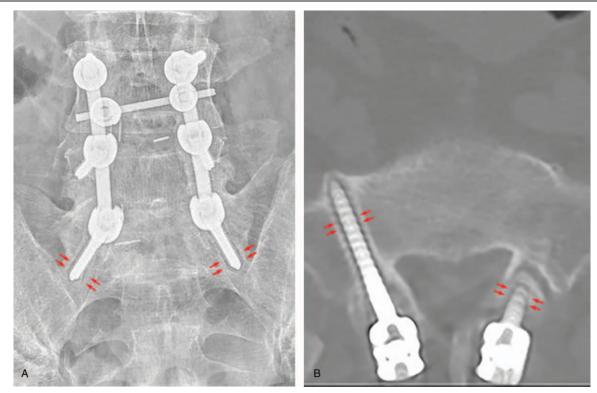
Under (A) plain radiograph, and (B) computed tomography, the halo phenomenon around the CBT screw (red arrows) was defined screw loosening. CBT = cortical bone trajectory.
